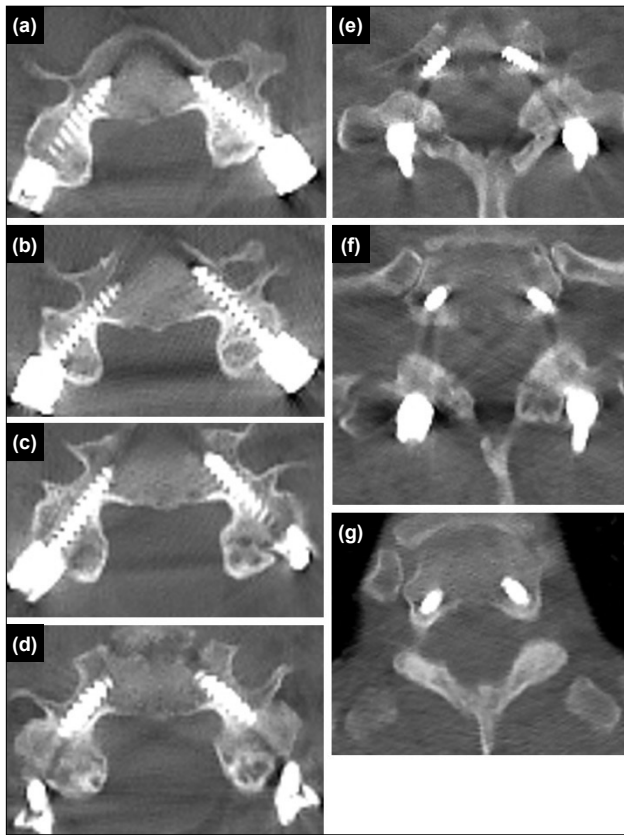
(a-g) Postoperative axial computed tomography (CT) images from C3 to T2.
